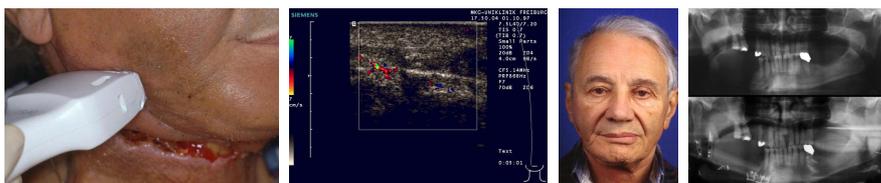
Secondary mandibular reconstruction using a free fibula flap was performed 18 months after resection of squamos cell carcinoma and postoperative irradiation with 60 Gy. At postoperative day six a wound healing disturbance occurred and a vascular complication was suspected (Fig. 7). Normal perfusion of the anastomoses and of nutrient vessels entering the free bone flap (arrow) were demonstrated (Fig. 8). Revisional surgery was therefore not performed. Postoperative view of the patient (Fig. 9). Preoperative X-Ray after mandibular reconstruction (Fig. 10).
